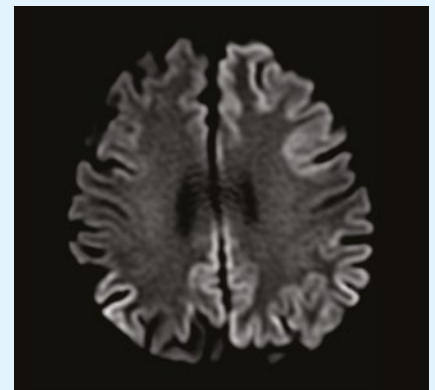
MRI showing Cortical Restricted Diffusion
